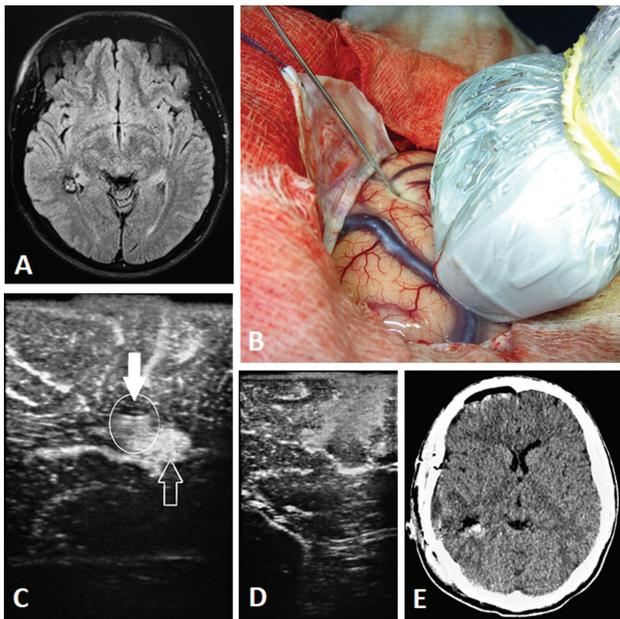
(A) Preoperative T2-fluid-attenuated inversion recovery (FLAIR) MRI scan showing a lesion adjacent to the right ventricular atrium. (B) The IOUS guiding the metal probe to the lesion. (C) The IOUS demonstrating the reverberation caused by the metallic probe (full white arrow and circle) and the hyperechoic lesion (white hollow arrow). (D) Control IOUS showing complete resection. (E) Postoperative CT scan confirming complete resection.
